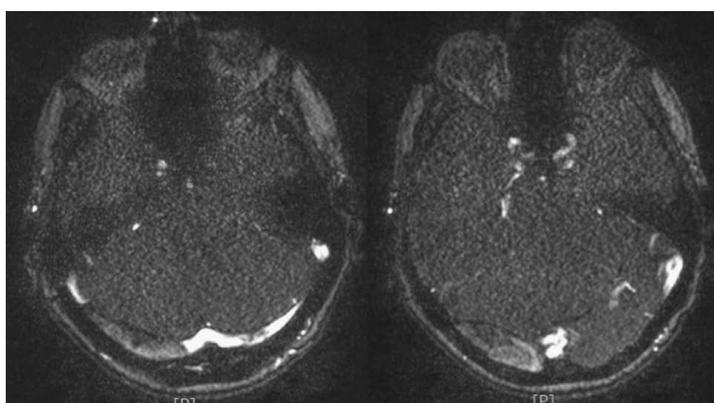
Angio-magnetic resonance imaging documenting the absence of the blood signal within the sinus as well as the epidural hematoma compressing the cerebellum and the sinus wall.
